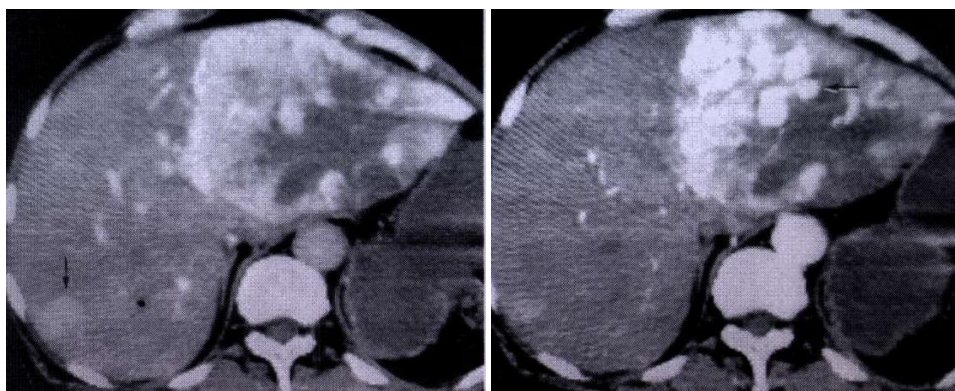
CT scanning: liver metastases in renal cancer
